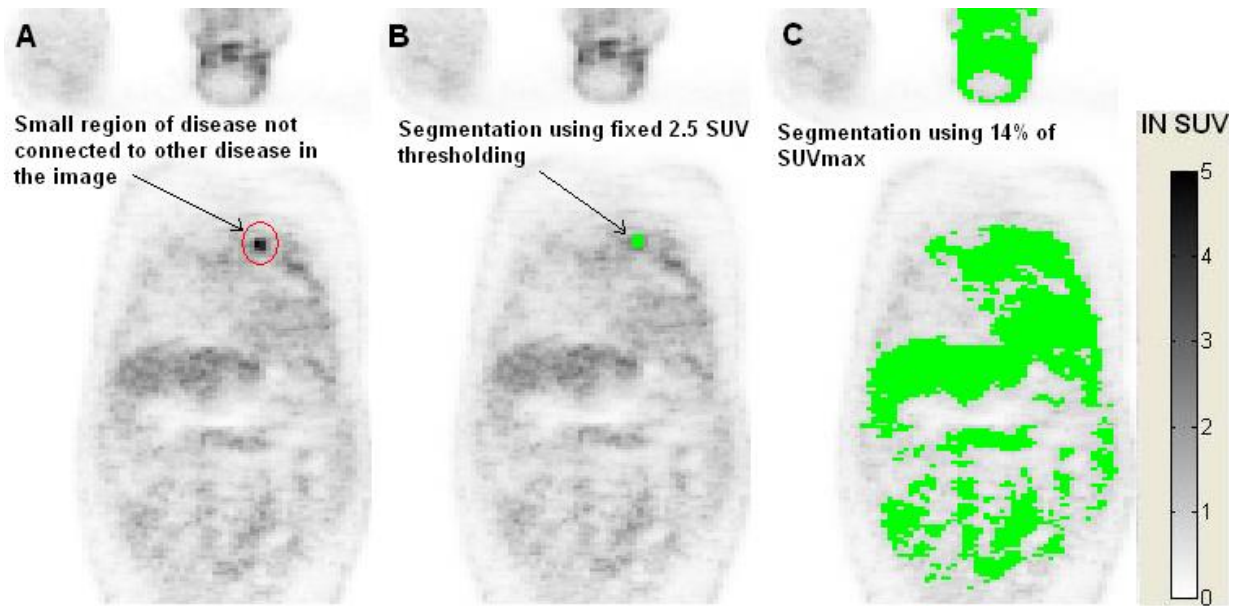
Issues with Segmentation using a Percentage of SUV_{max}
